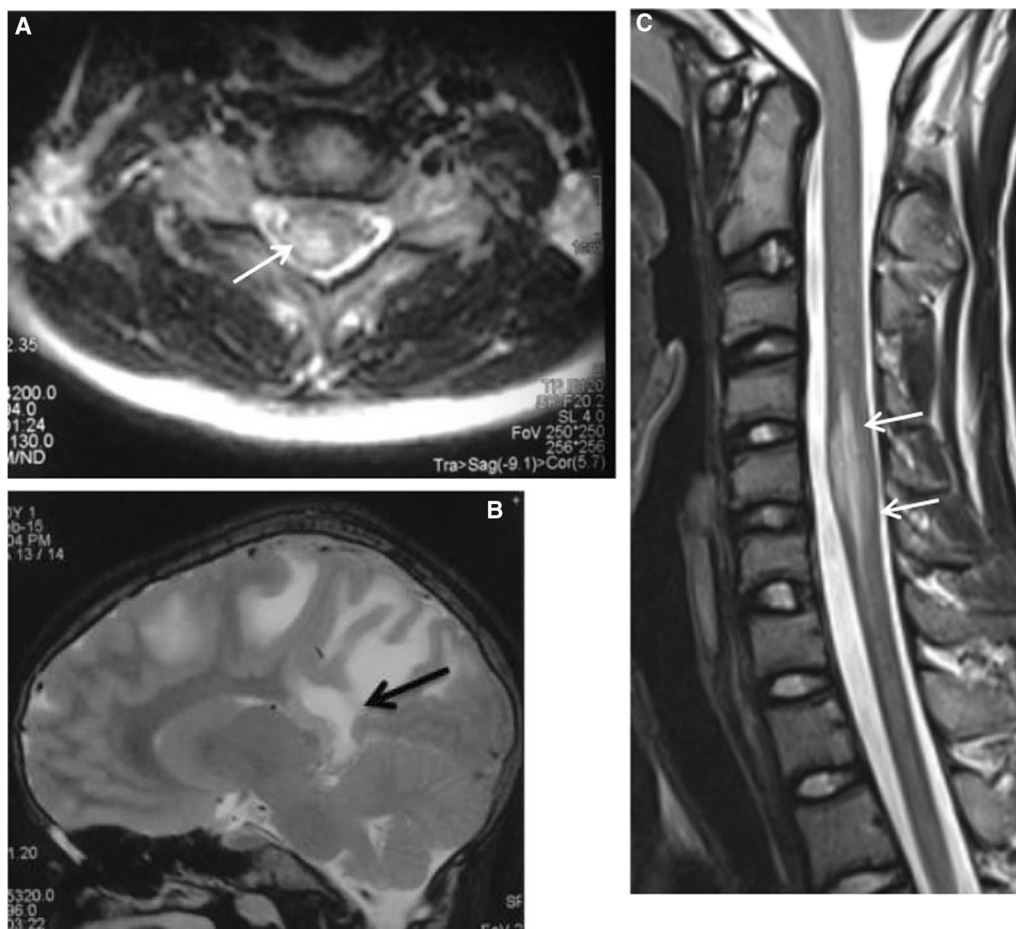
Multiple sclerosis in a 13-year-old female who presented with paraparesis. T2W axial MR image of the upper cervical spine (A) shows a peripherally located wedge shaped hyperintense lesion (white arrow) which involves less than half of the cross-sectional area of the spinal cord. Sagittal T2W image of the brain (B) of the same patient demonstrates patchy areas of T2 hyperintensity in pericallosal and periventricular distribution (black arrow). Sagittal T2W MR image of the cervical and upper thoracic spine (C) in another case of diagnosed MS shows a short segment hyperintense area within the cervical spinal cord (white arrows)
